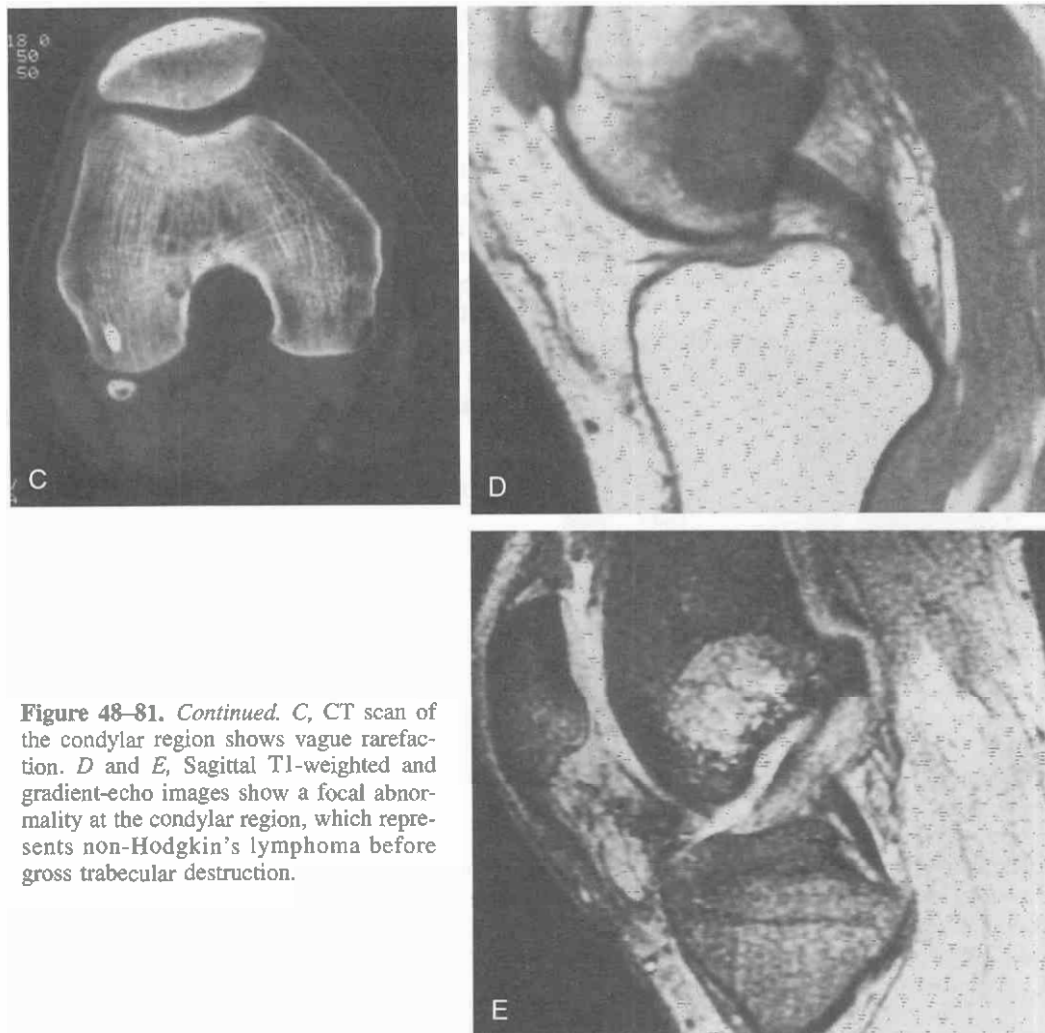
Continued. C, CT scan of the condylar region shows vague rarefaction. D and E, Sagittal T1-weighted and gradient-echo images show a focal abnormality at the condylar region, which represents non-Hodgkin's lymphoma before gross trabecular destruction.
